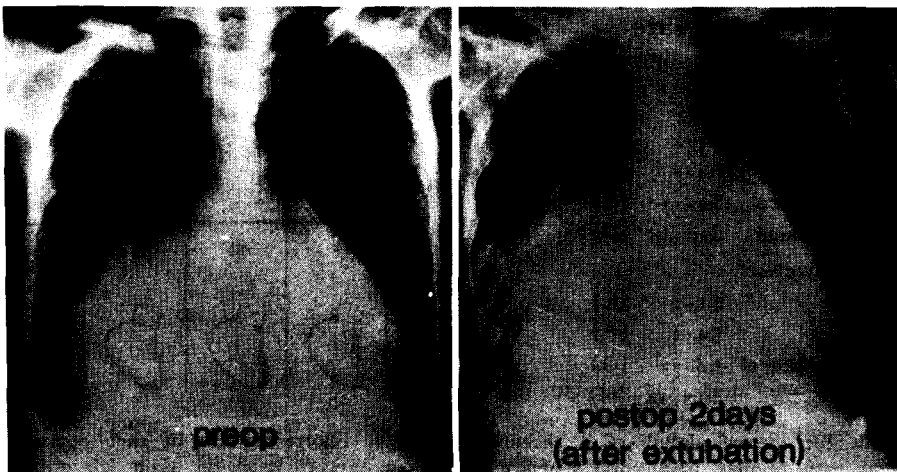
Chest x-ray film of type III
